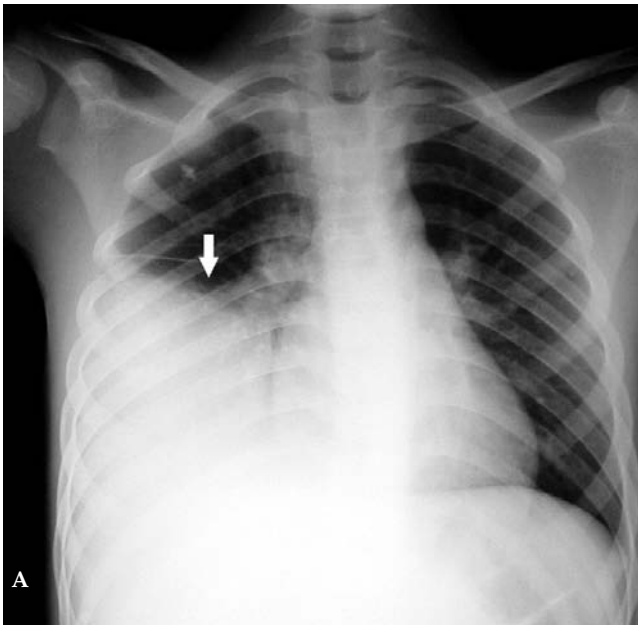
Anteroposterior (A) and lateral (B) chest radiographs in September 2003, showing marked elevation of the right hemidiaphragm (arrow), with right-sided fissural thickening indicating an associated right-sided pleural effusion.
